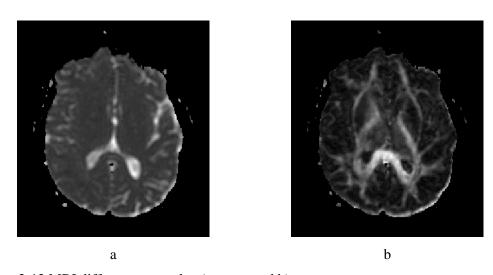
MRI different protocols: a) *p*-map and b) *q*-map.
